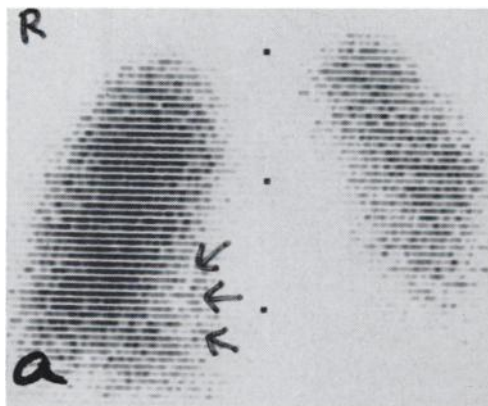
Posterior vascular scan showing general decreased activity on the left side with a definitely decreased area of activity in the right medial basal segment, where a cavity was seen by x-ray.
